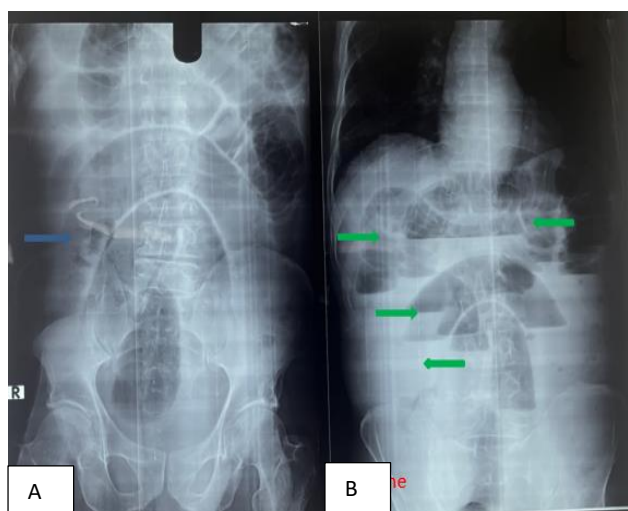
(A and B): Preop non contrast X-ray abdomen supine view of centrally located dilated small bowel (blue arrow) and erect view with multiple air fluid level (green arrow).
